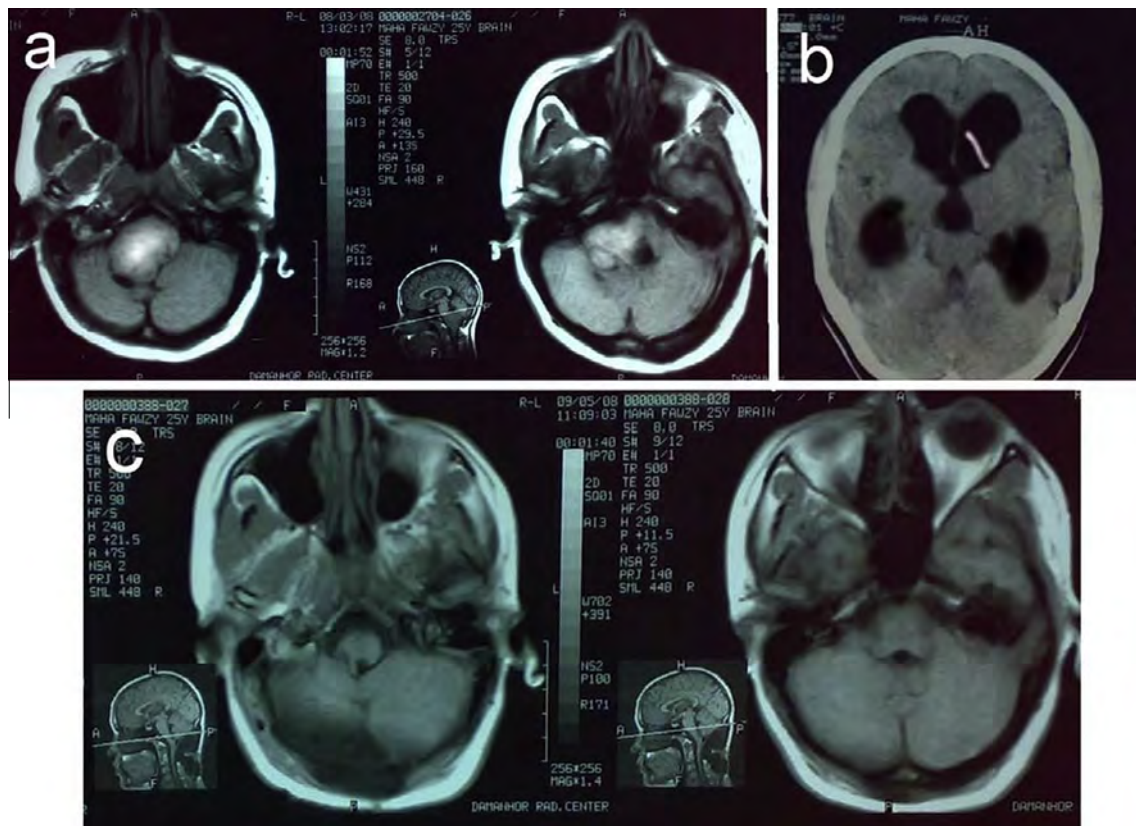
(a) Preoperative MRI of a pilocytic astrocytoma, with mass effect occluding the 4th ventricle, causing obstructive HC. (b) Postoperative CT complete tumor excision without HC.
